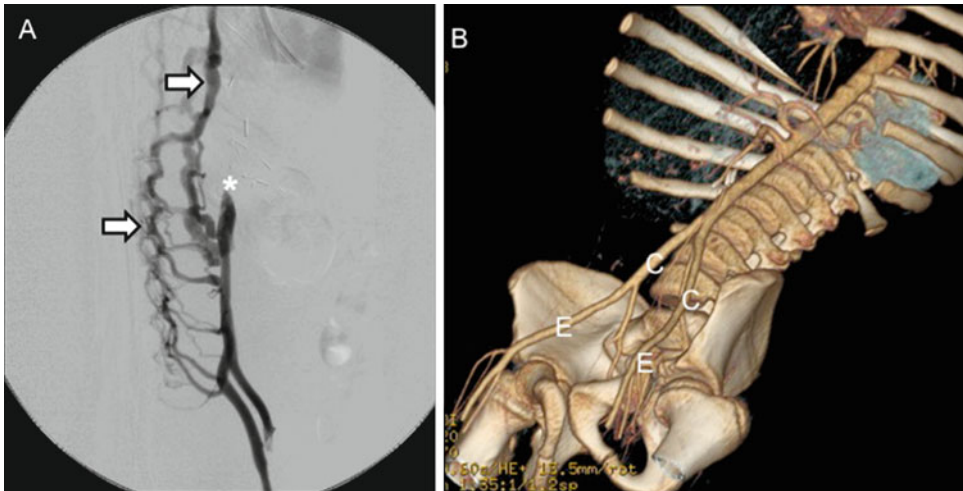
Imaging studies used to further evaluate abdomino-pelvic vascular anatomy following abnormal Doppler ultrasound screening: (a) Venogram demonstrating occluded inferior vena cava (*) with prominent collaterals
